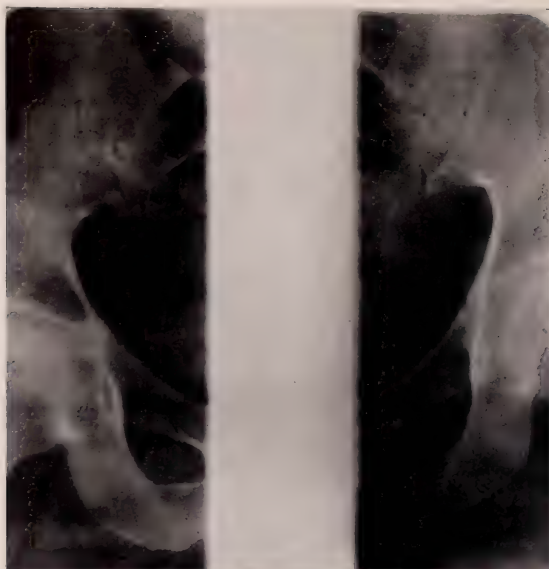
Roentgenogram of the pelvis made with the x-ray beams employed in the divided field technique.
